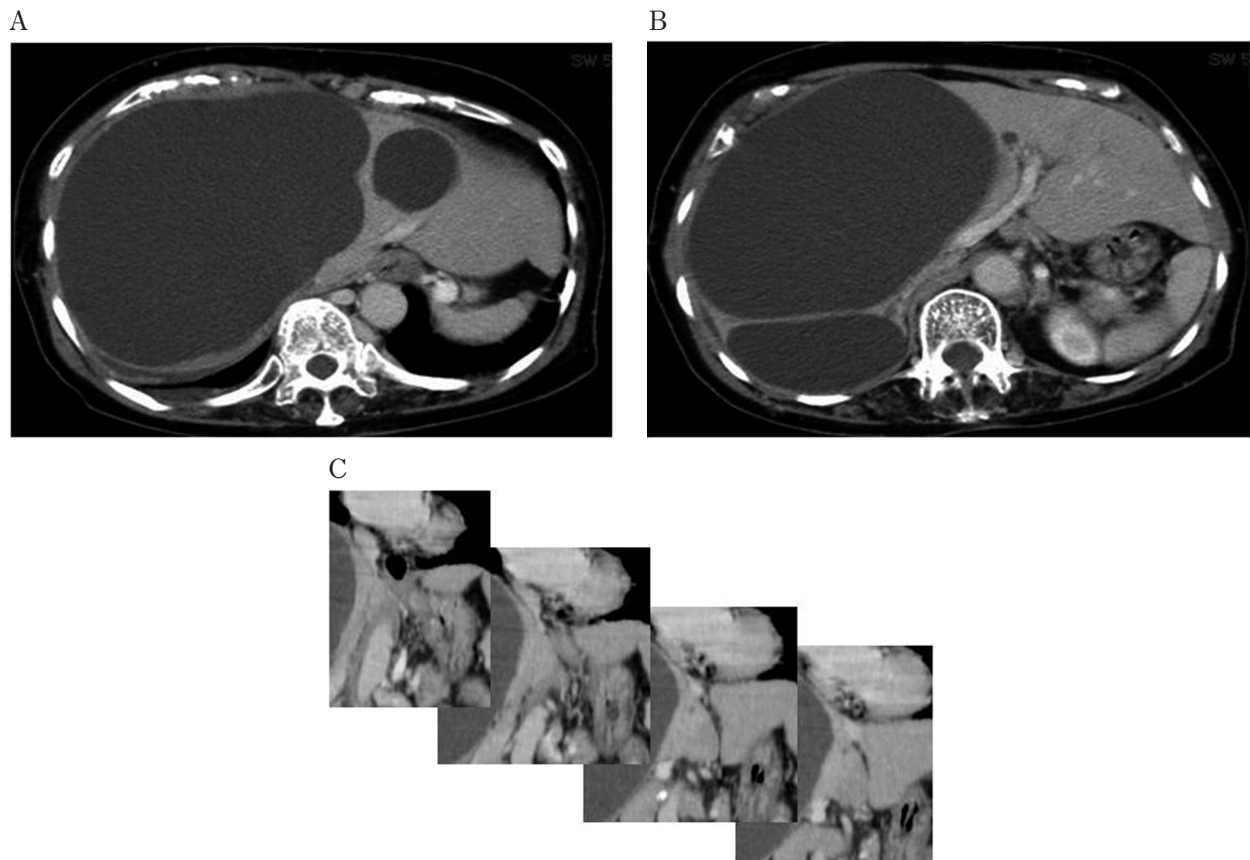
Contrast-enhanced computed tomography demonstrates large hepatic cysts occupying the right lobe of the liver, the largest of which was 19 cm in diameter (Fig. 1A). Of the hepatic parenchyma in the right lobe, only segment 6 remained. The right portal branch, right hepatic vein, and middle hepatic vein were not recognizable because of the hepatic cysts.
